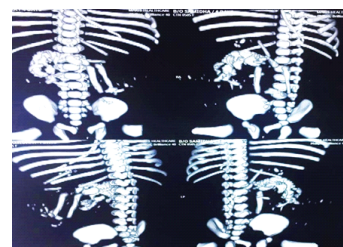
CT scan showing fetal skeleton
